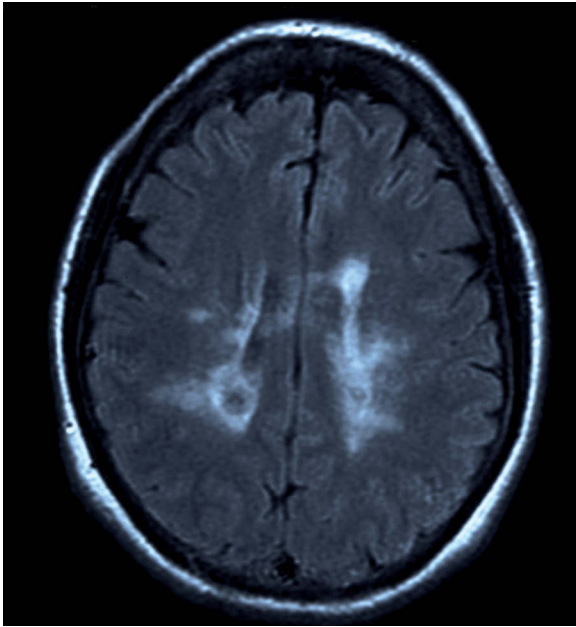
Cranial MRI showing demyelinating lesions in periventricular white matter.
